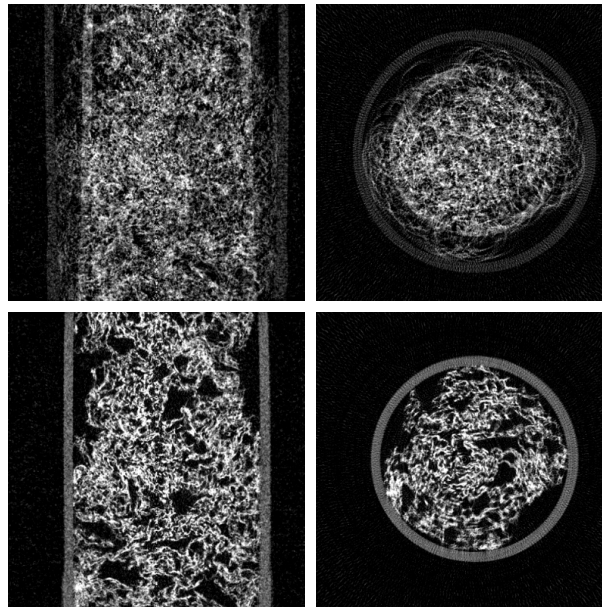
Cross-sectional (left) and axial (right) CT slices of a sponge in a tube reconstructed without (top) and with (bottom) auto-calibration based on DCC. The used micro CT scanner is pictured in Figure 1.1. Figure re-printed from [J31].
